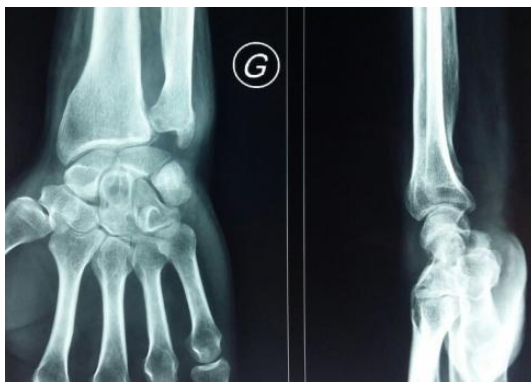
Anteroposterior and lateral radiographic images of the wrist : showed geodes affecting the distal ulna scaphoid and capitatum
